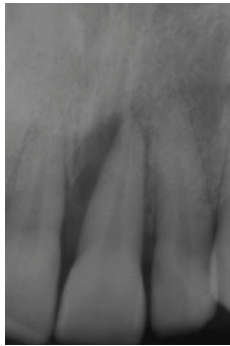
Periapical X-ray at baseline.
